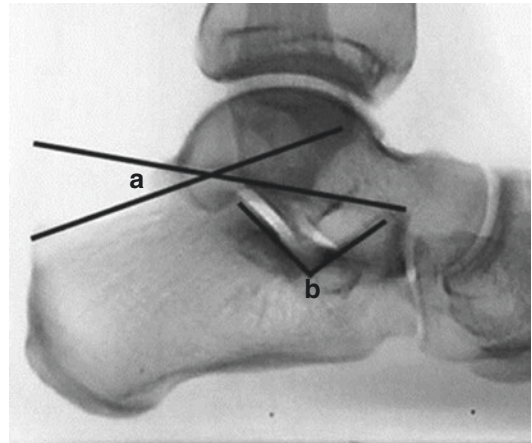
Normal lateral radiograph of the foot showing (a) Bohler's angle and (b) crucial angle of Gissane (Image from *Core Knowledge in Orthopedics: Trauma*)
